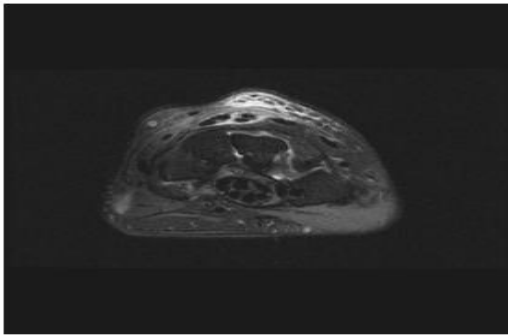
MRI left hand showing enhancement around extensor tendons
